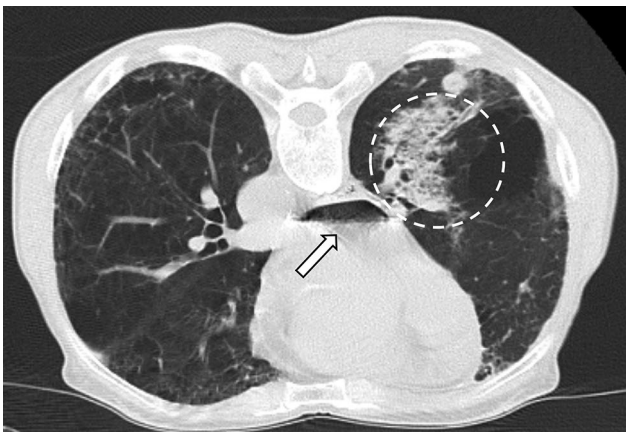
A computed tomography image taken immediately after lung biopsy for a nodule in the right middle lobe. An air-fluid level in the left atrium (arrow) and infiltrative opacity surrounding the nodule (circle) are observed.
